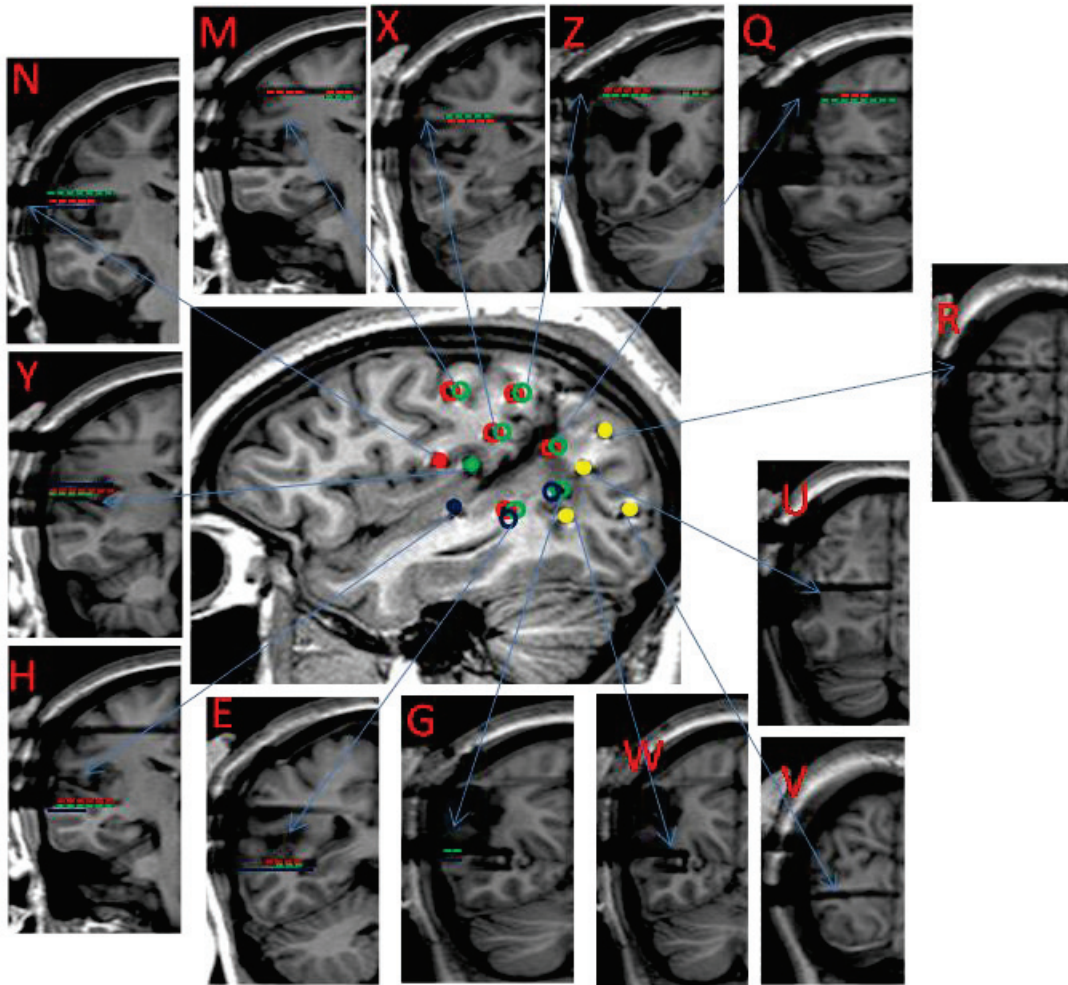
8: Patient 8 MRI with electrodes in place (right hemisphere). Central sagittal image: each insular electrode is represented by a unique colored solid circle; non-insular electrodes are represented by empty circles with the color of each of the insular electrode they are responding to. Yellow solid circles are for non responding electrodes. Peripheral coronal images: a cross-section of each electrode with its name and its responding contacts (responses are indicated by color coded dotted lines, representing the color of the corresponding stimulated insular electrode).
